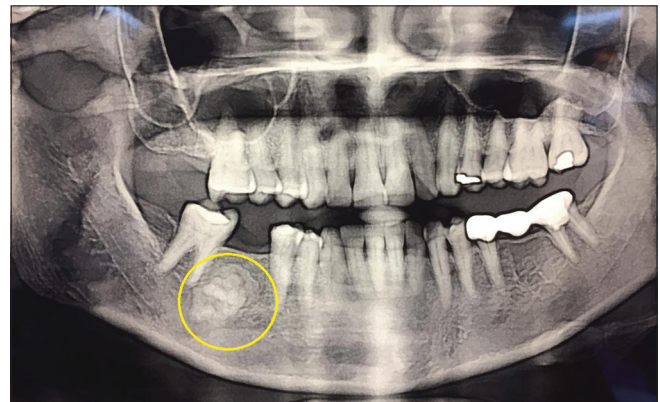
Orthopantomogram showing a well-defined radiopaque mass in the right mandible region extending from the distal root of 45 to the mesial root of 47
